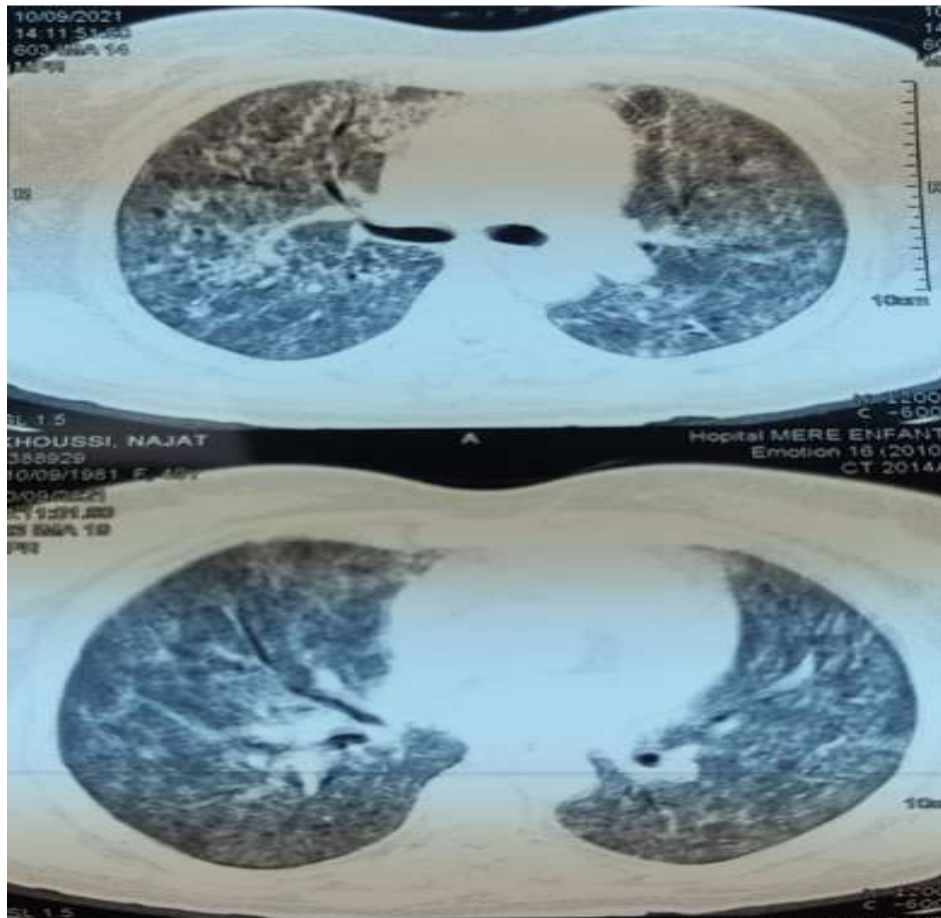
Chest CT after 15 days of hospitalization and start of nintedanib treatment.
